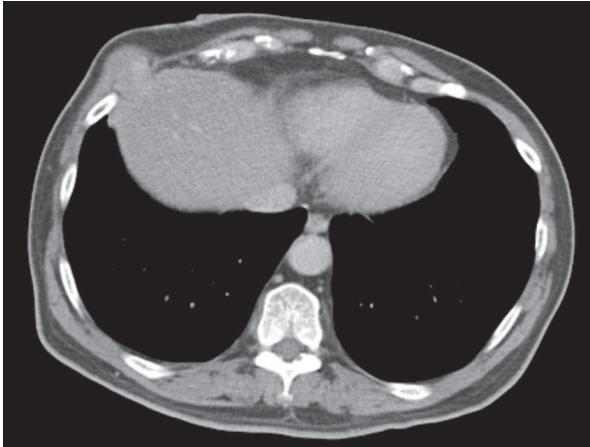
Three years after the second surgery, a chest computed tomography axial view found a right chest wall tumor adjacent to the previous surgical site.
